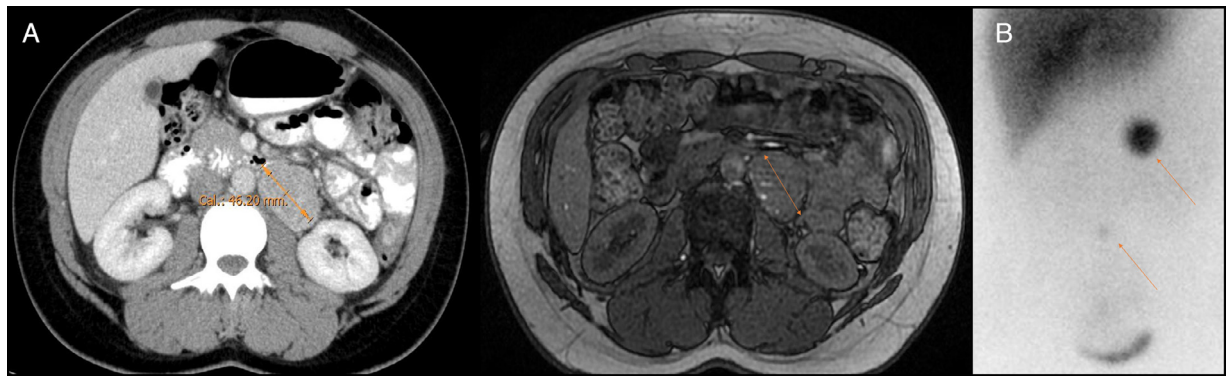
(A) CT and MRI axial slices showed a 5 cm left paraaortic infrarenal tumor. (B) ^{123}I -MIBG scintigraphy showing high intensity uptake in the lesion described in CT/MRI concerning with a paraganglioma. And another more caudal uptake, of smaller size and intensity in the retroperitoneal space at the level of L5.
